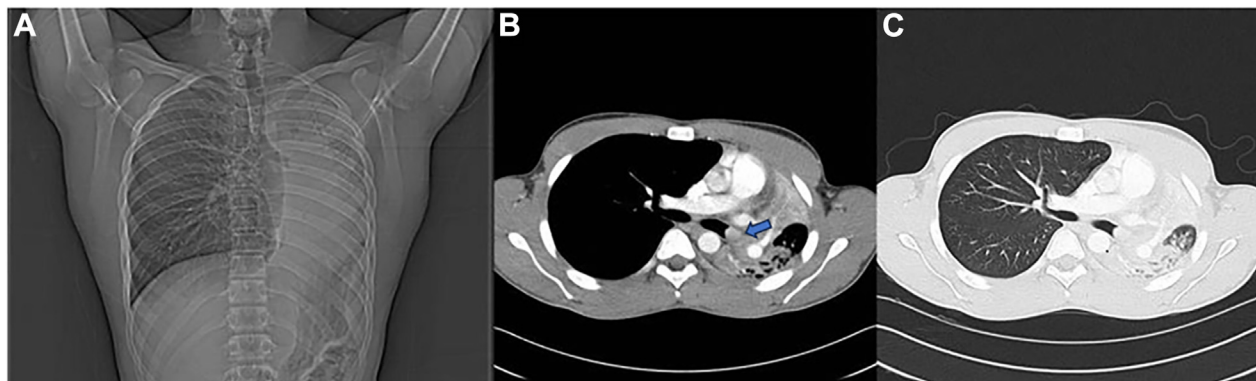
(A) Scout film of the patient's chest shows complete collapse of the left lung with mediastinal shift to the left and silhouette of lesion occluding left mainstem bronchus. (B, C) Computed tomography images of the chest show a well-circumscribed mass completely obstructing the lumen of left distal bronchus (arrow).
